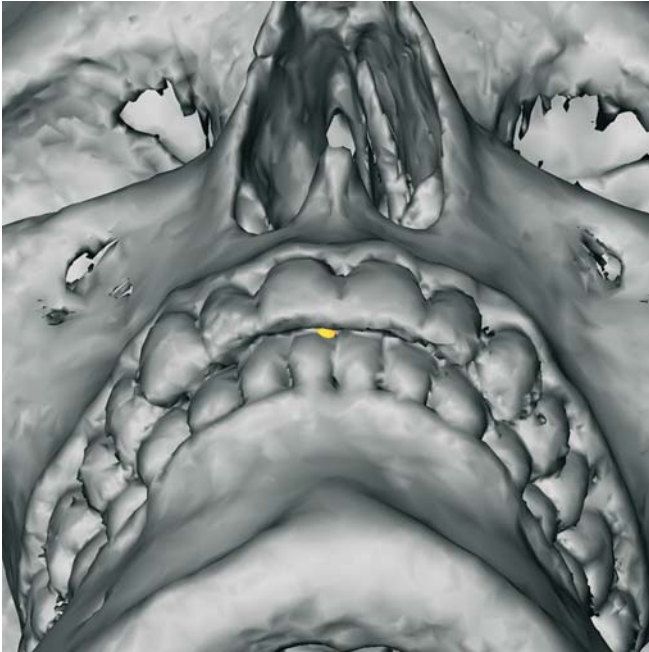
Lower Incisor_r, Submental view (3-D CT, patient K.C.)
